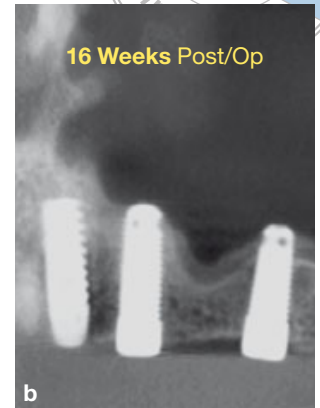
CBCT (sagittal view) 16 weeks after the procedure, demonstrating the formation of bone in the tent.
